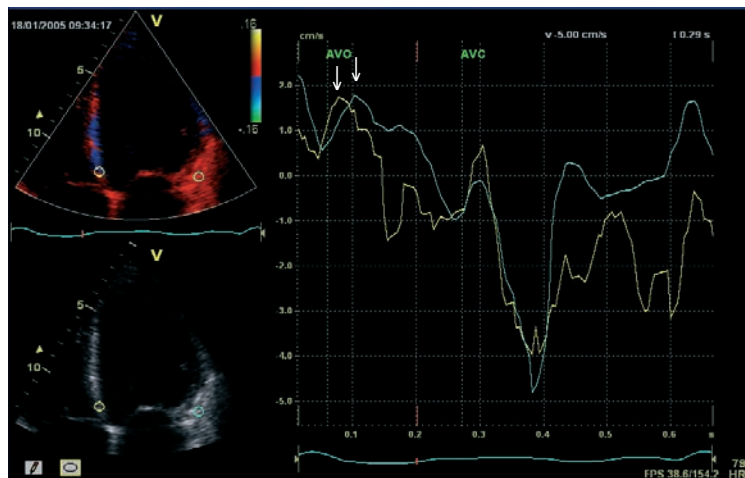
Left ventricular dyssynchrony assessment using color-coded tissue Doppler imaging. The sample volumes are placed in the basal part of the septum and lateral wall, and tracings are derived. The arrows indicate the peak systolic velocity (first peak = septum and second peak = lateral wall (AVO = aortic valve opening, AVC = aortic valve closure)). The septal-to-lateral delay is 40 ms, indicating the absence of substantial left ventricular dyssynchrony (same patient as in Figure 2).
